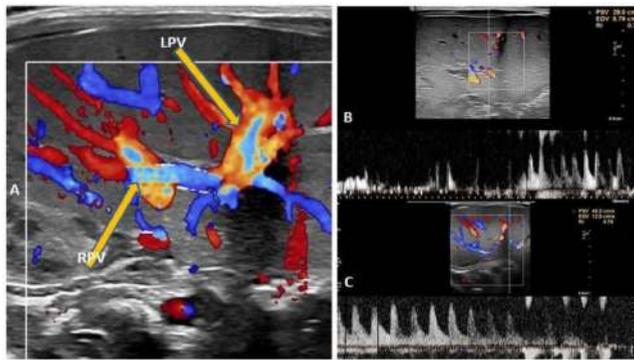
In the postprandial color Doppler US examination of the patient with partially recanalized left portal vein thrombosis, markedly increased blood flow signals in LPV (arrow) were detected (A). In the Doppler examination of the same patient, the left HARI was 0.70 at the postprandial 4th hour (fasting) (B), while the HARI was 0.76 in the postprandial examination (C). *RPV: right portal vein, LPV: left portal vein.*
